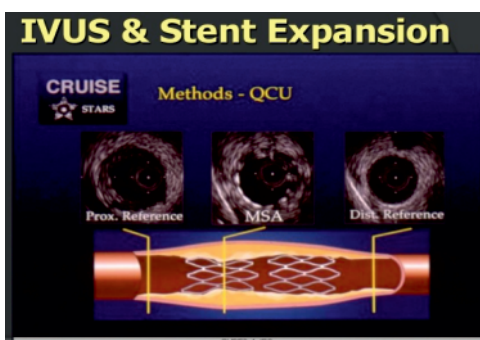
Intravascular ultrasound and stent expansion
